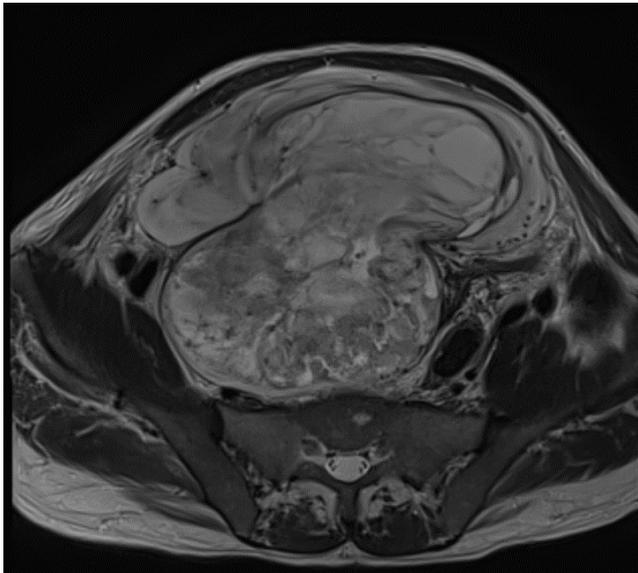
b) Abdominopelvic MRI: T2 axial
